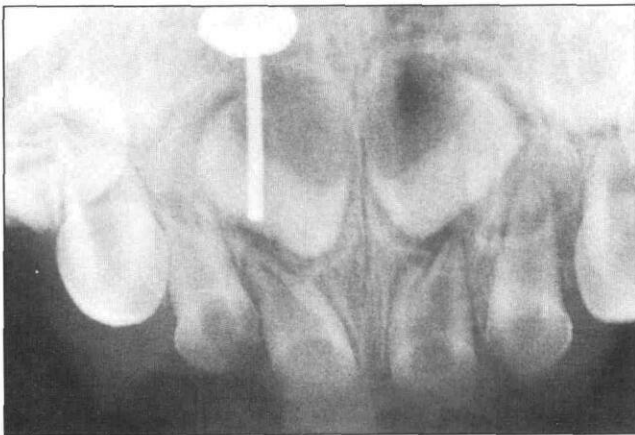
Maxillary occlusal radiograph showing carious maxillary incisor teeth and superimposed radiopacity.
